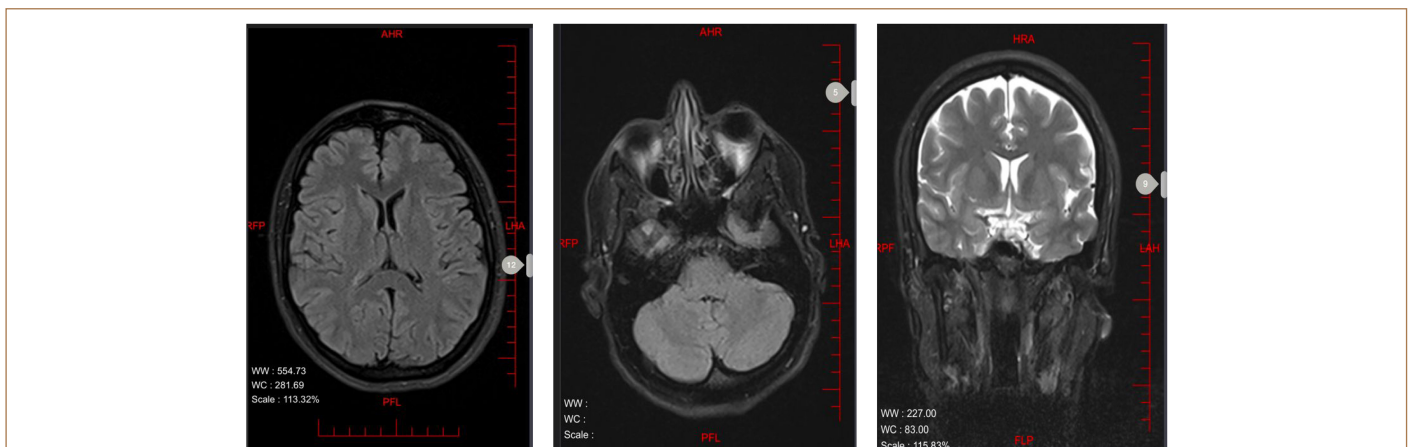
Normal brain magnetic resonance imaging images showing no structural abnormalities.
